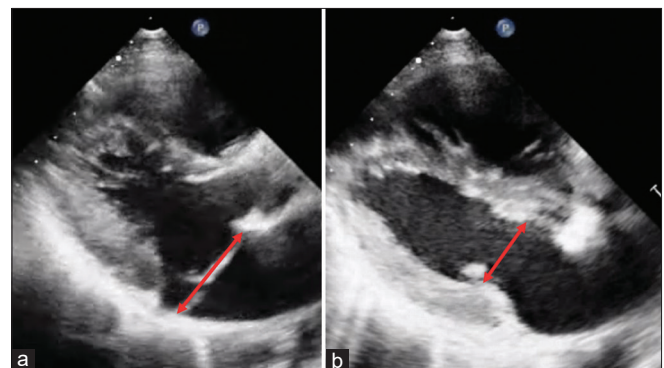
Parasternal long-axis images showing mitral annular diameter in (a). Systole (b). Diastole
